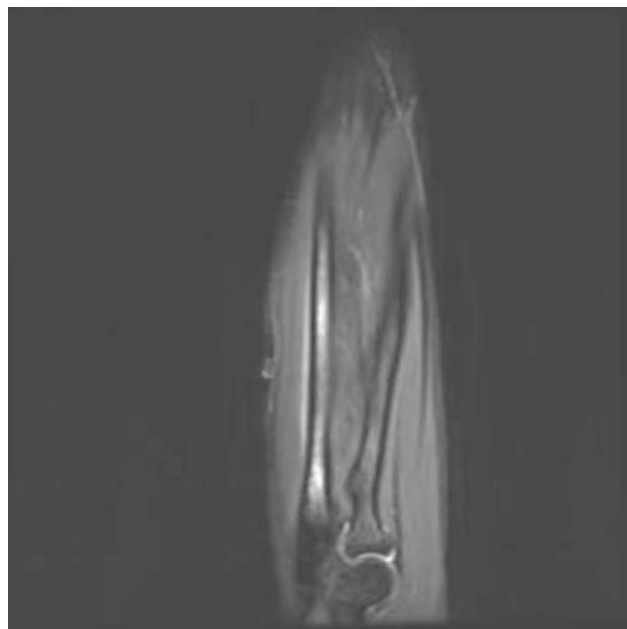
Fat-suppressed T2 MRI of the right forearm demonstrates bone marrow edema consistent with stress fracture on the proximal ulna. MRI indicates magnetic resonance imaging.
